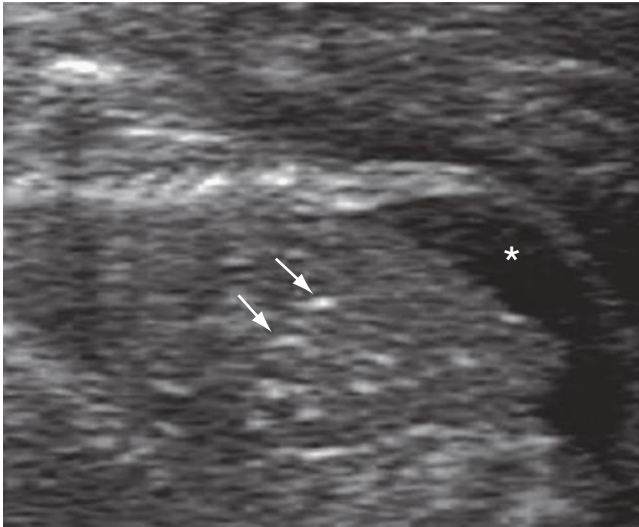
Sonogram of a second trimester fetus with proven cytomegalovirus infection. Hepatic calcifications (arrows) are seen as well as fetal ascites (asterisk).
